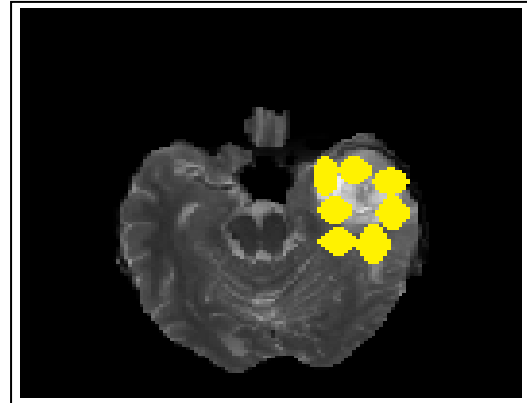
MSER Feature of MRI
